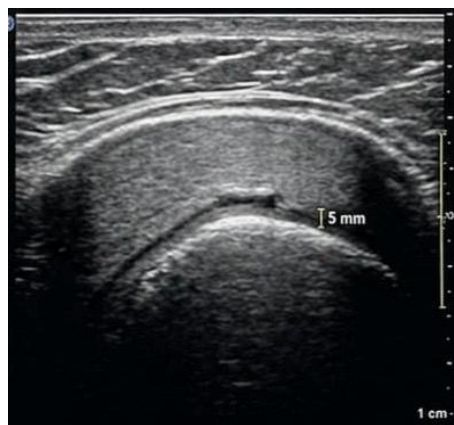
Representative ultrasound image of knee joint
